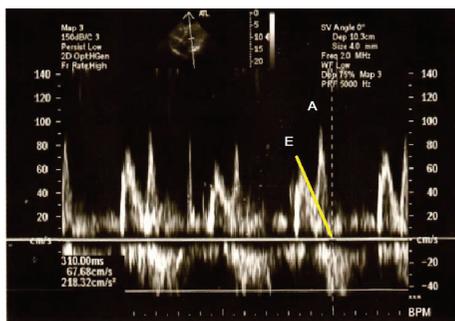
Diagnosing diastolic dysfunction with echocardiography. Transmittal flow velocities measured with pulsatile wave Doppler technique. The ratio (E/A) of the early diastolic peak velocity (E) and the late diastolic velocity (A) is lower than 1. Deceleration time (DT) is the interval from the peak of the wave E to its end (marked with a yellow line). In this case, its prolongation was measured (310sec). The above alterations prove the left ventricular diastolic dysfunction (relaxation disorder).
